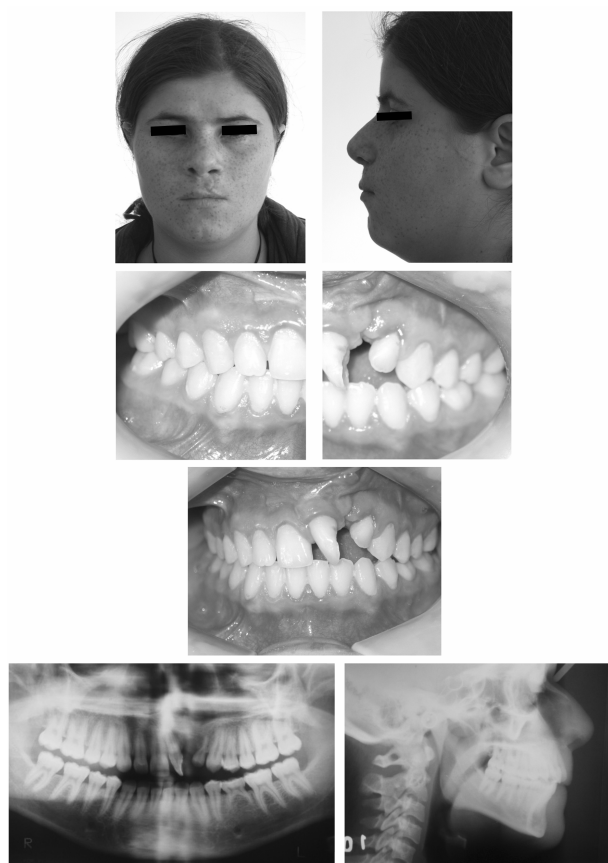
Extraoral, intraoral photographs and radiographs before orthodontic treatment.
